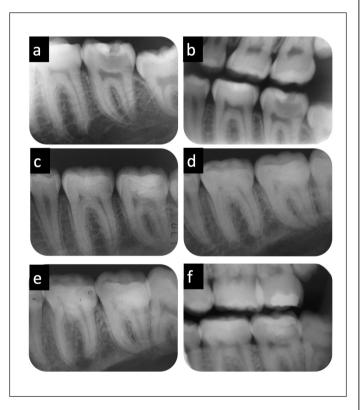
Periapical (a) and bitewing (b) radiographic images of deep caries lesion in 37. Radiographic images after one (c), two (d), and five years after treatment (e, f).
